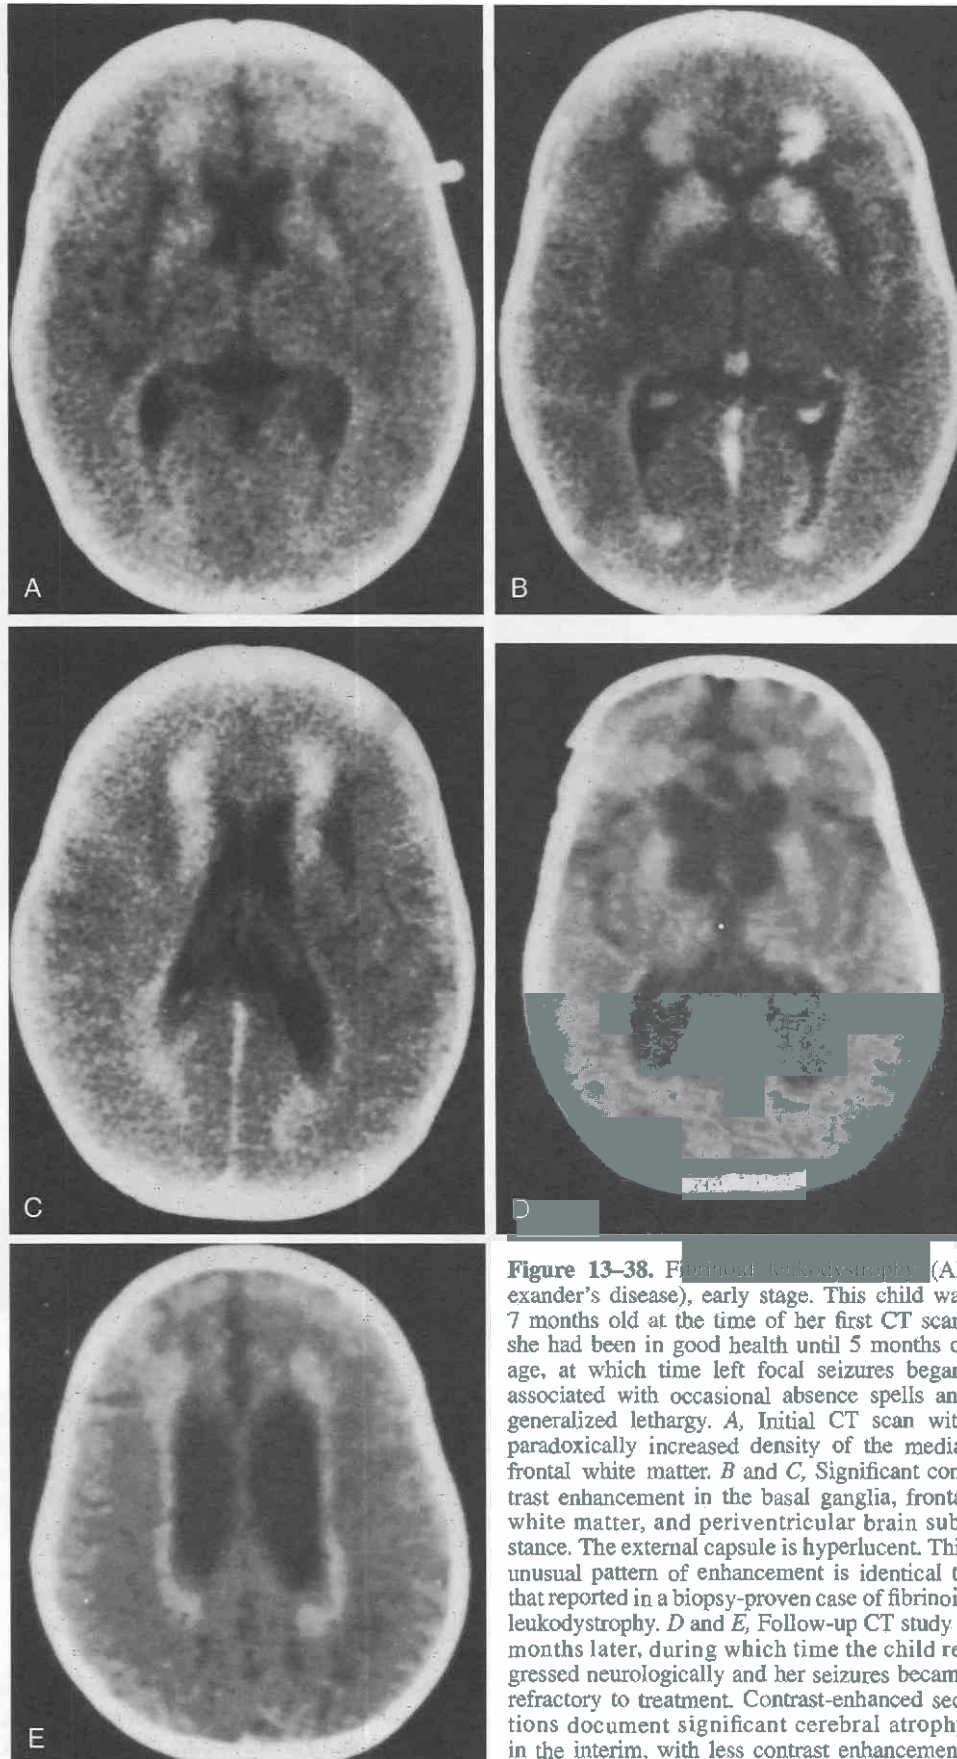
Fibrinoid leukodystrophy (Alexander's disease), early stage. This child was 7 months old at the time of her first CT scan; she had been in good health until 5 months of age, at which time left focal seizures began, associated with occasional absence spells and generalized lethargy. *A*, Initial CT scan with paradoxically increased density of the medial frontal white matter. *B* and *C*, Significant contrast enhancement in the basal ganglia, frontal white matter, and periventricular brain substance. The external capsule is hyperlucent. This unusual pattern of enhancement is identical to that reported in a biopsy-proven case of fibrinoid leukodystrophy. *D* and *E*, Follow-up CT study 8 months later, during which time the child regressed neurologically and her seizures became refractory to treatment. Contrast-enhanced sections document significant cerebral atrophy in the interim, with less contrast enhancement.
